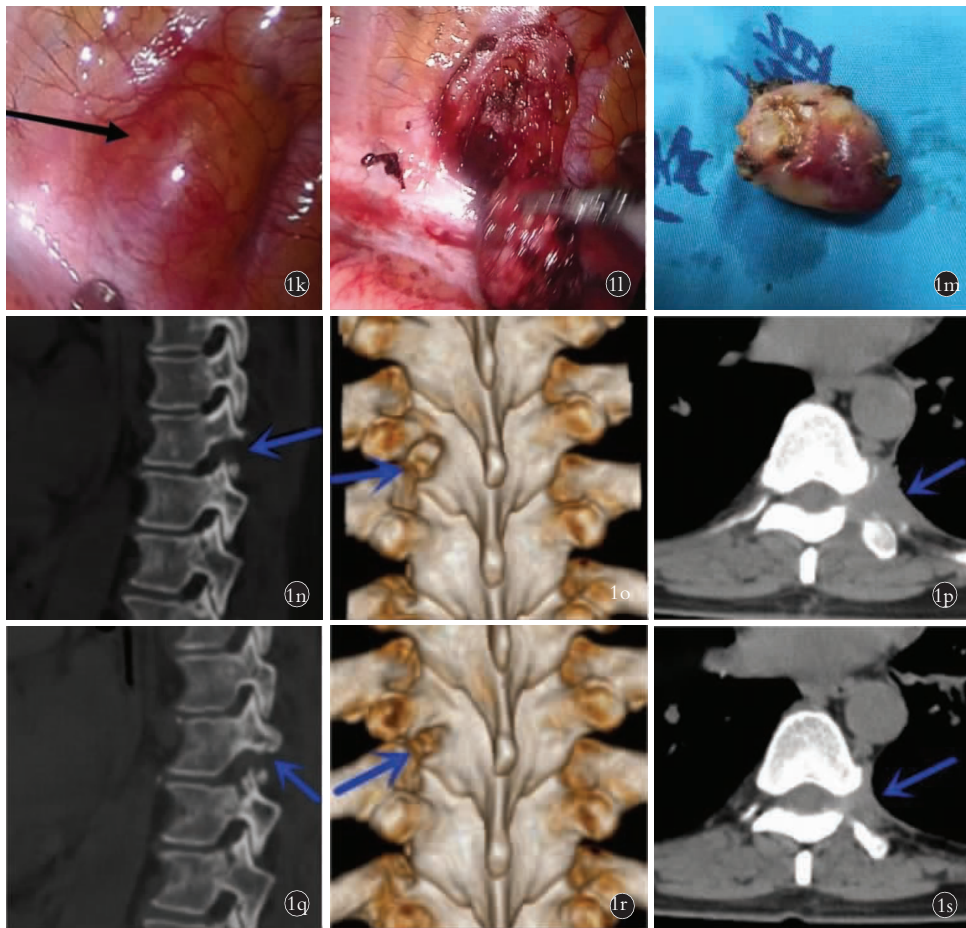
患者,女,52 岁,胸椎哑铃型肿瘤(神经鞘瘤) 1k. 胸腔镜下显露肿瘤 1l. 胸腔镜下分离并完整切除肿瘤 1m. 完整切除的肿瘤大小为 2.7 cm×1.7 cm×1.5 cm 1n. 术后第 2 天手术部位 CT 矢状位影像,箭头所指为术中去除骨质造成的骨性缺损 1o. 术后第 2 天三维 CT 重建(箭头所指为术中去除骨质造成的骨性缺损) 1p. 术后第 2 天胸部 CT(箭头所指处为手术创腔) 1q. 术后 1 年手术部位 CT 矢状位影像,骨质缺损部位可见明显的骨质生长 1r. 术后 1 年三维 CT 重建,骨性缺损范围较前明显缩小 1s. 术后 1 年胸部 CT 显示手术创腔明显变小,胸膜光滑,神经鞘瘤无复发
